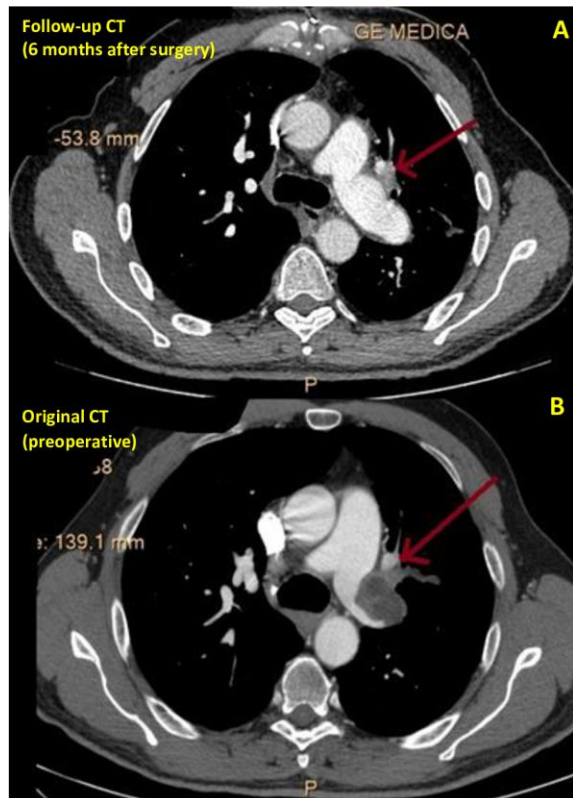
Six months after surgery, a CT showed complete resolution of the hydatid cyst membranes and thrombotic lesions in the left main pulmonary artery. In 3A, the arrow shows the intravascular filling defect in left upper segmental artery.
